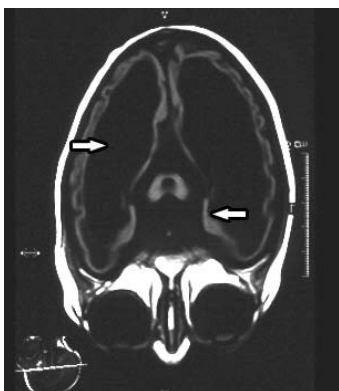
Brain MRI of family I, patient 2, showing loss of predominantly white matter and some gray matter with atrophy of the basal ganglia.
